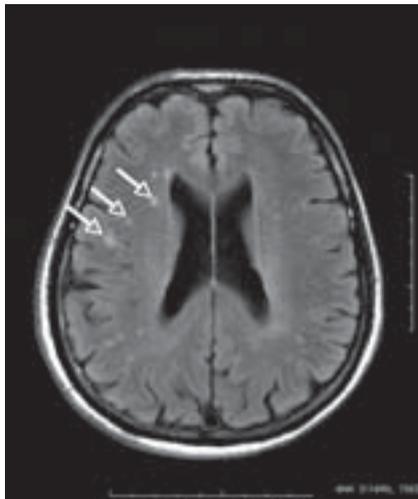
MRI showing white matter lesions (arrows).
